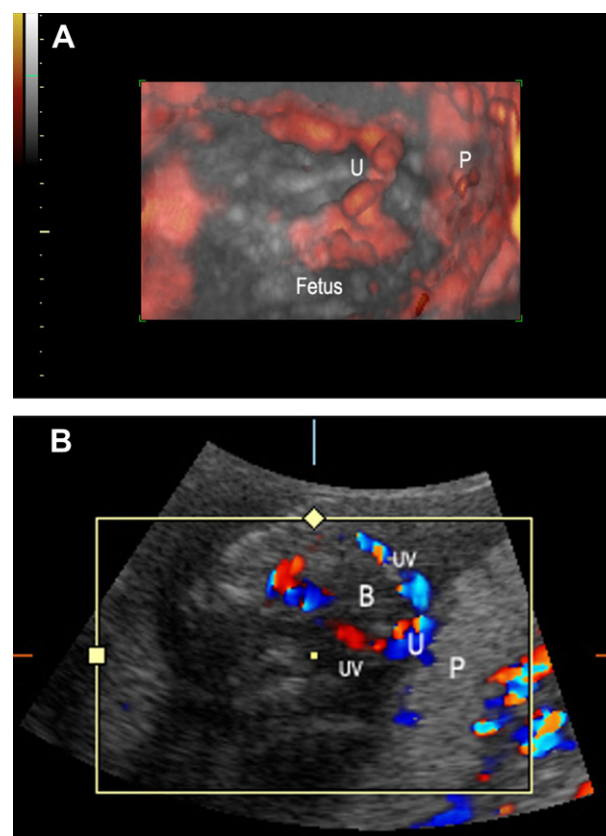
Color Doppler angiography showing (A) a short umbilical cord and (B) umbilical vessels surrounding the enlarged urinary bladder. B = bladder; P = placenta; U = umbilical cord; UV = umbilical vessels.
